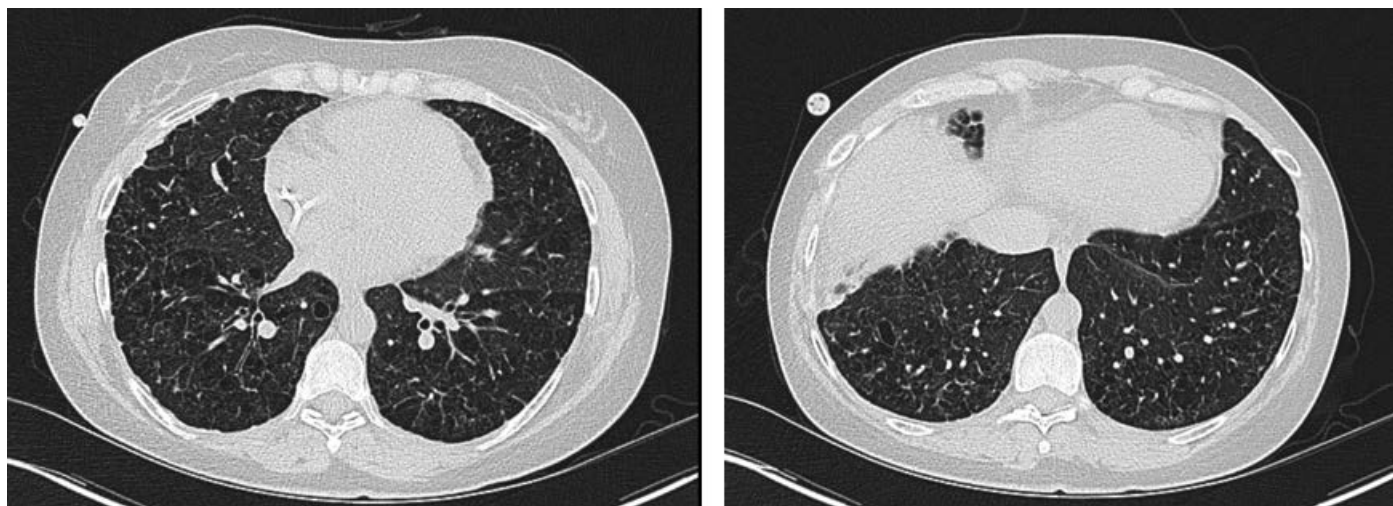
33-year-old female with pulmonary Langerhans cell histiocytosis by biopsy complicated by severe pulmonary hypertension. Computed tomography images with thin-walled, irregular cysts, architectural distortion of the lungs, and small nodules. Initiated on sildenafil, macitentan, and intravenous treprostinil with improvement in pro B-type natriuretic peptide and 6-minute walk. Referred for lung transplant evaluation.
